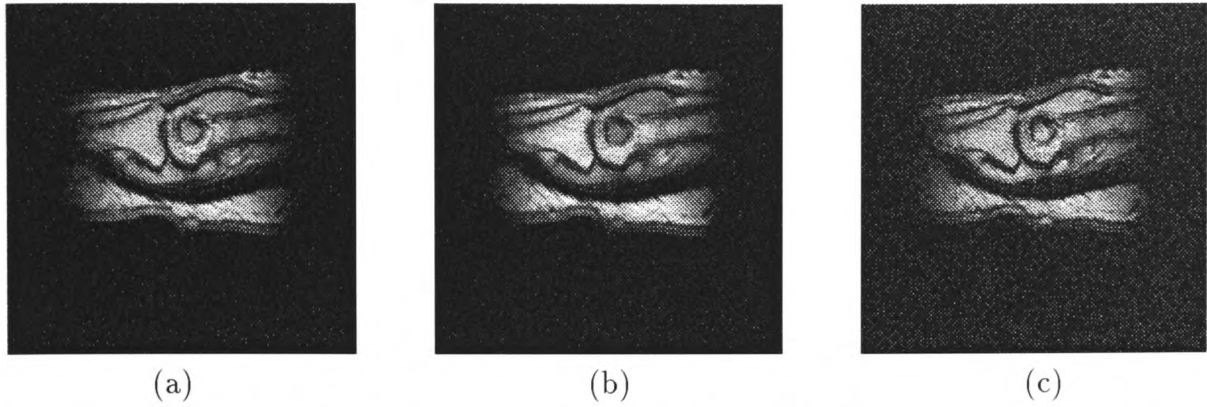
(a) PD-weighted image standardized and contrast stretched (b) T2-weighted image standardized and contrast stretched (c) T1-weighted image standardized and contrast stretched.
